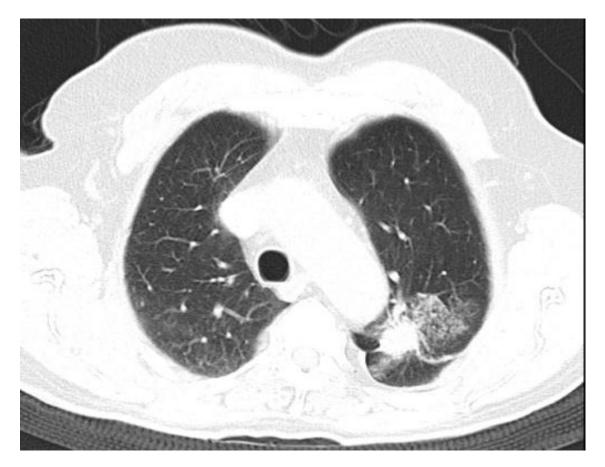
Post biopsy CT chest image of 77 year old showing ground glass attenuation adjacent to a spiculated left upper lobe lung mass consistent with parenchymal haemorrhage
